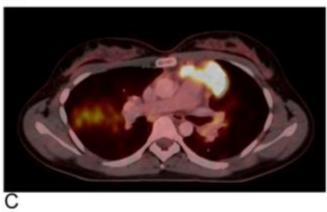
Abbreviations: CT = computed tomography; CTV = clinical tumor volume; PET = positron emission tomography.
